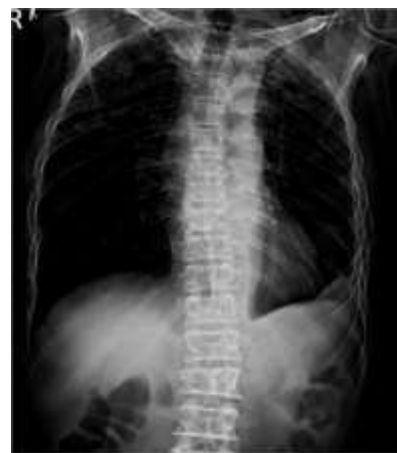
PA spine radiograph showing multiple osteolytic lesions
